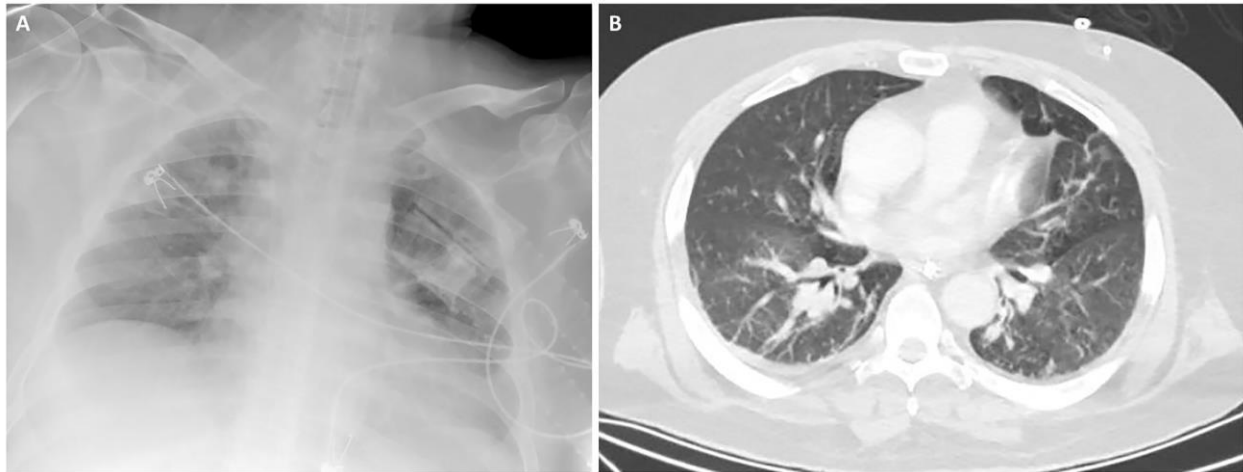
A. X-ray chest graphy and; B. Thorax CT axial section showing nodular infiltrations in medial region.
